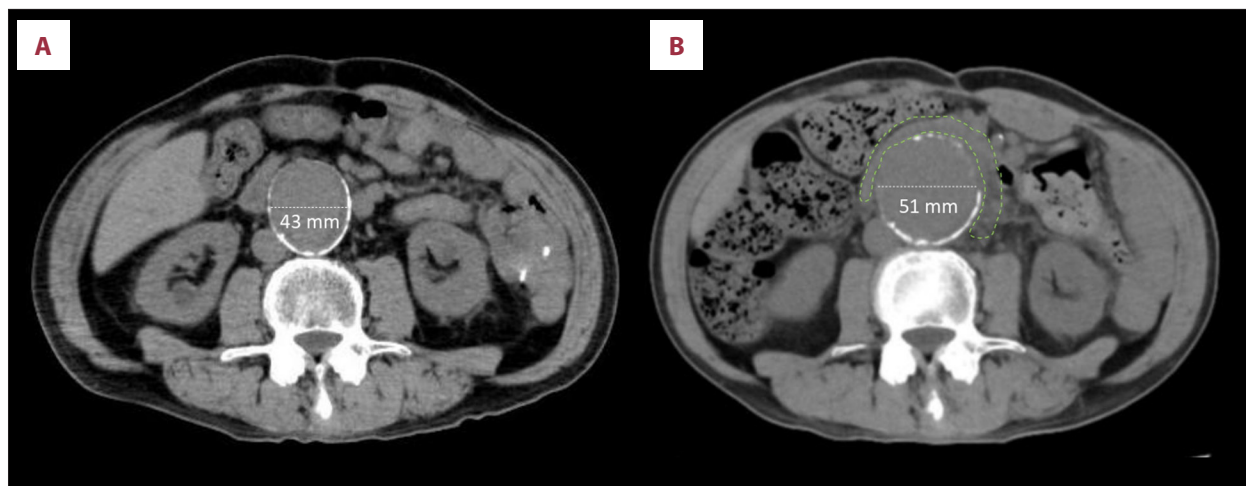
Serial non-contrast computed tomography images showing rapid abdominal aortic aneurysm enlargement after COVID-19 diagnosis. (A) Axial non-contrast computed tomography image obtained 35 days before coronavirus disease 2019 (COVID-19) diagnosis, demonstrating an abdominal aortic aneurysm (AAA) measuring 43 mm in maximal short-axis diameter. (B) Axial non-contrast computed tomography image obtained 18 days after COVID-19 diagnosis, showing rapid aneurysm enlargement to 51 mm in maximal short-axis diameter, accompanied by increased periaortic fat attenuation (highlighted by the light green dashed outline), consistent with impending AAA rupture.
